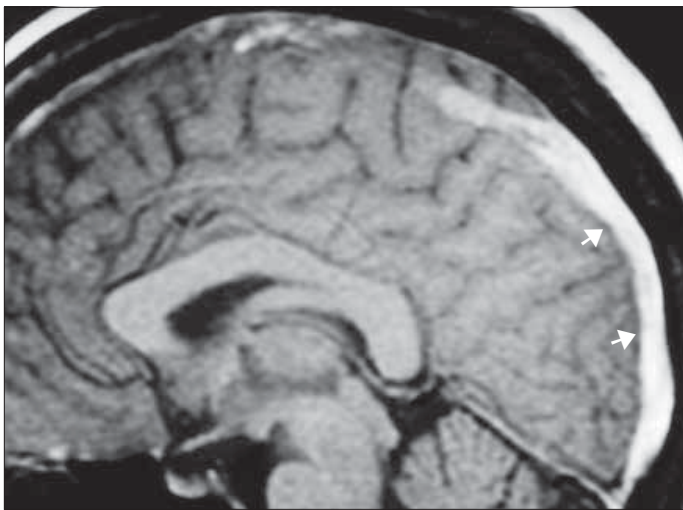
Sagittal T1-weighted magnetic resonance (MR) image shows a high-signal-intensity mass in the superior sagittal sinus (arrows).
